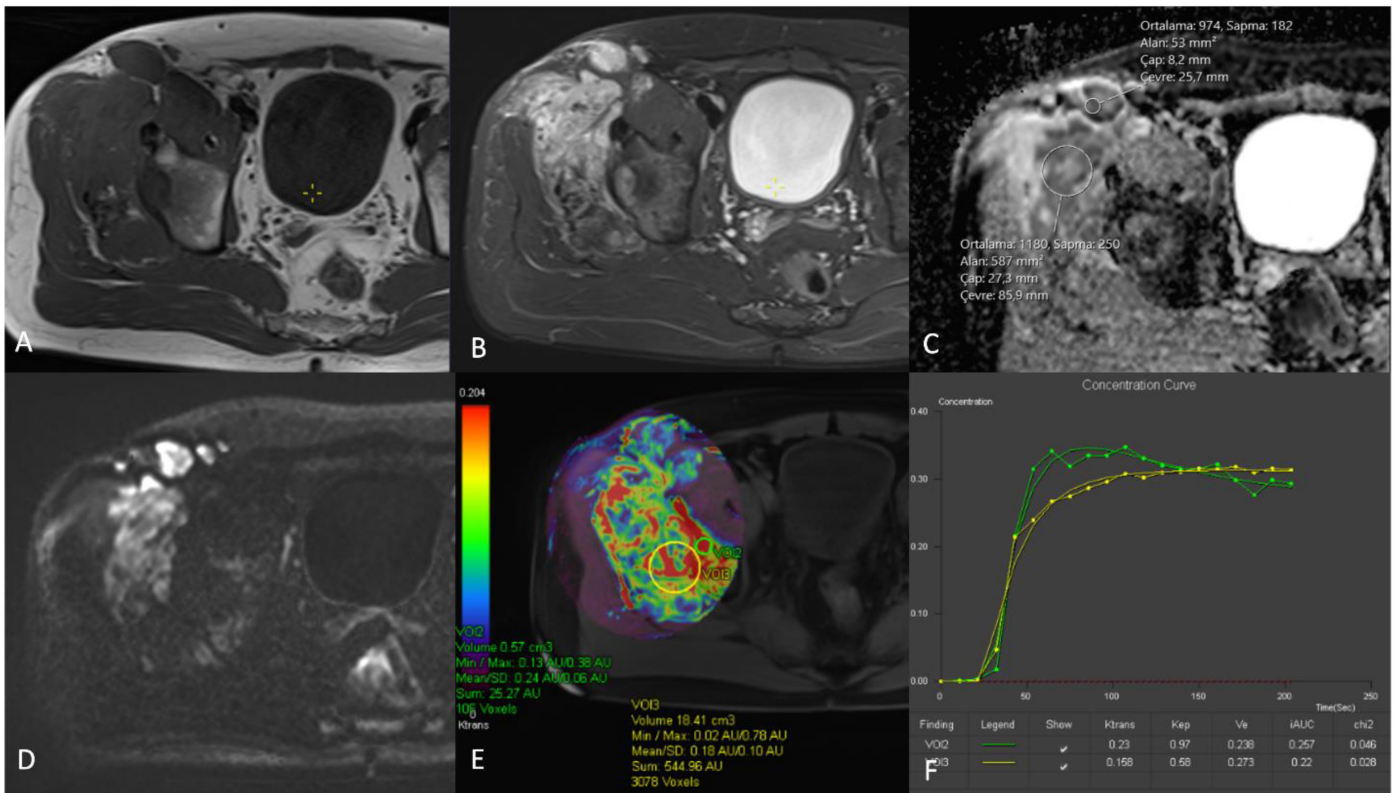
A 42-year-old male patient with myofibroblastic sarcoma (grade 1) of the right proximal thigh. A: axial T1WI. B: axial FS T2WI. C and D: ADC map, DWI (b800). E and F: Ktrans map and dynamic curves.
